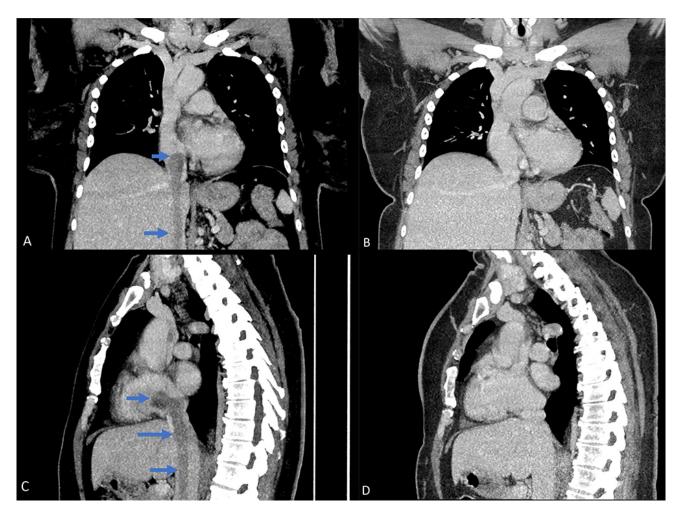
Partial response to GNRH agonist for woman presenting with venous involvement. CT thorax (Single portovenous phase post contrast) demonstrates tumour related thrombus extends through entire IVC into heart on pre-treatment images and resolution of IVC thrombus after 2 months of GNRH agonist. She had persisting disease in the low IVC and right common iliac vein (not shown). Coronal Images: (A) Pre-treatment scan. (B) Post treatment. Sagittal Images: (C) Pre Treatment. (D) Post treatment.
